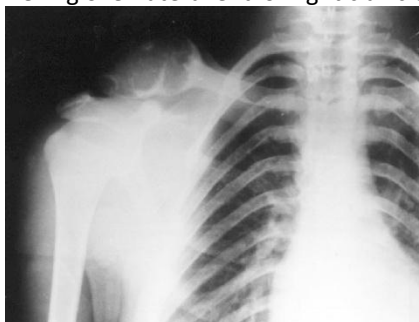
Antero-posterior radiograph of the clavicle.
